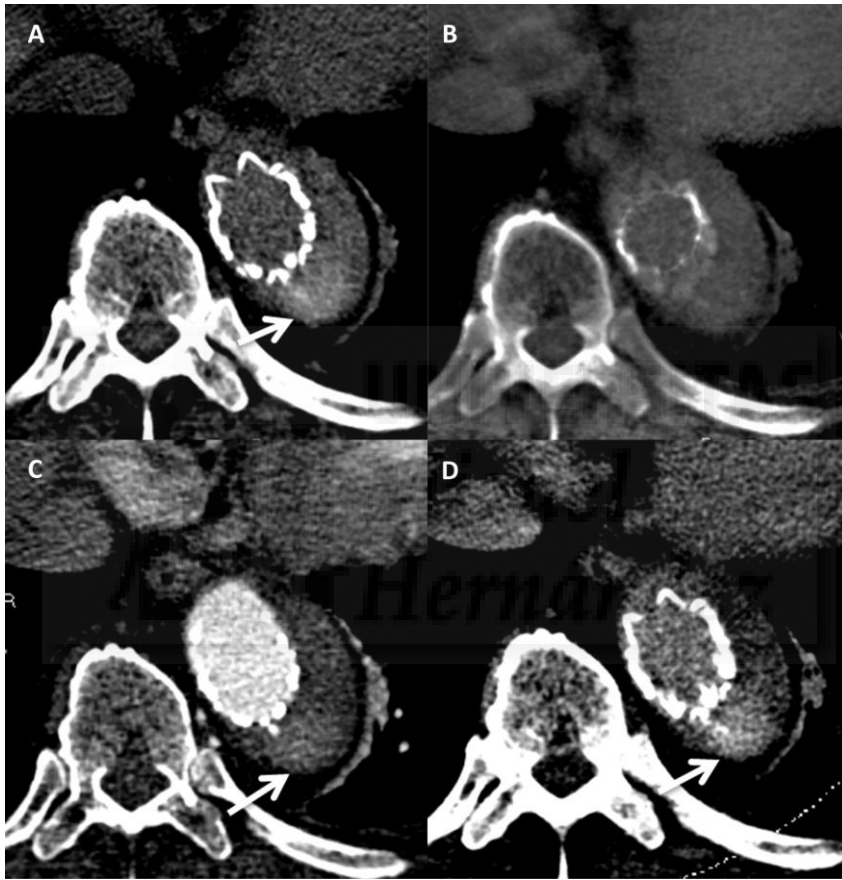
Reading Session B False Negative Case. 83-year old male with low-flow type II endoleak arising from a bronchial artery in follow-up CT 96 days after TEVAR for type B aortic dissection. Standard nonenhanced (a), virtual noncontrast (b), arterial phase (c) and DE WA delayed phase (d). Presence of contrast within the aneurysm sac beyond the graft (arrows) is correctly depicted
